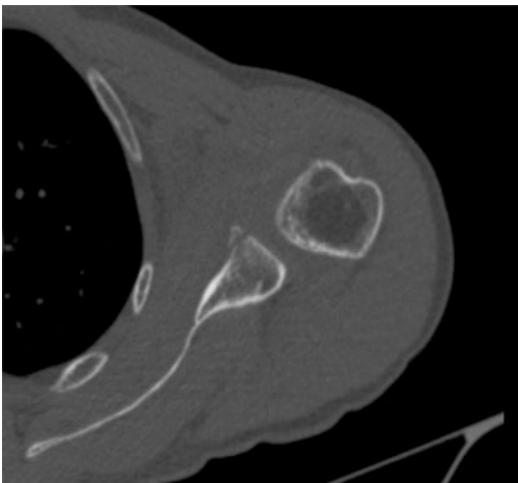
CT transverse scan
